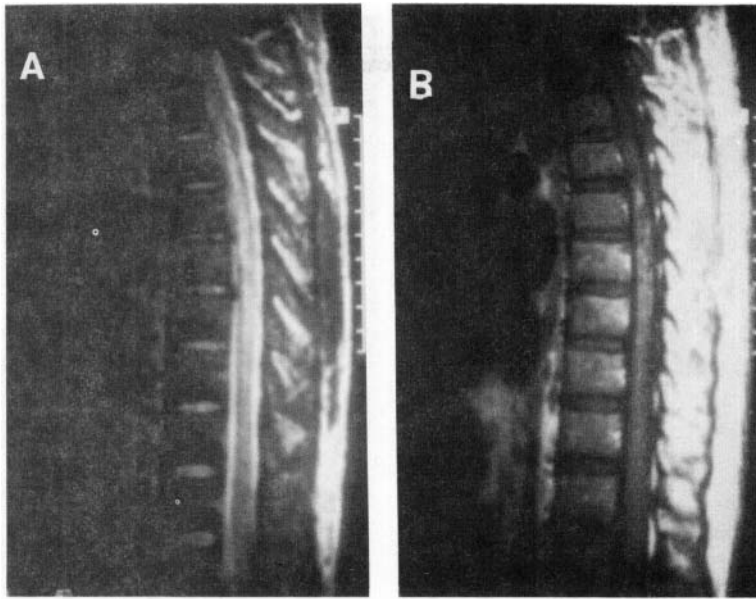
Parainfectious disseminated myelitis. T2-weighted image (a) of the dorsal spine shows areas of hyperintensities in the cord with partial sparing in between the lesions. T1-weighted image (b) shows foci of hyperintensities in the middorsal cord suggesting small areas of hemorrhage.
